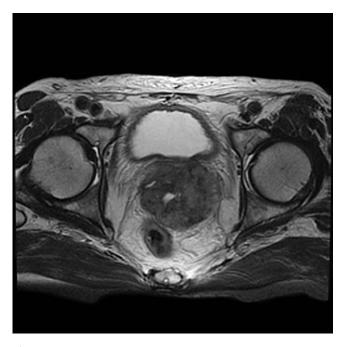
Magnetic resonance imaging showing an enlarged prostate with symmetrical expansion and compression of the rectum and urinary bladder. The tumor was largely confined to the prostate without evidence of direct involvement of adjacent organs.
